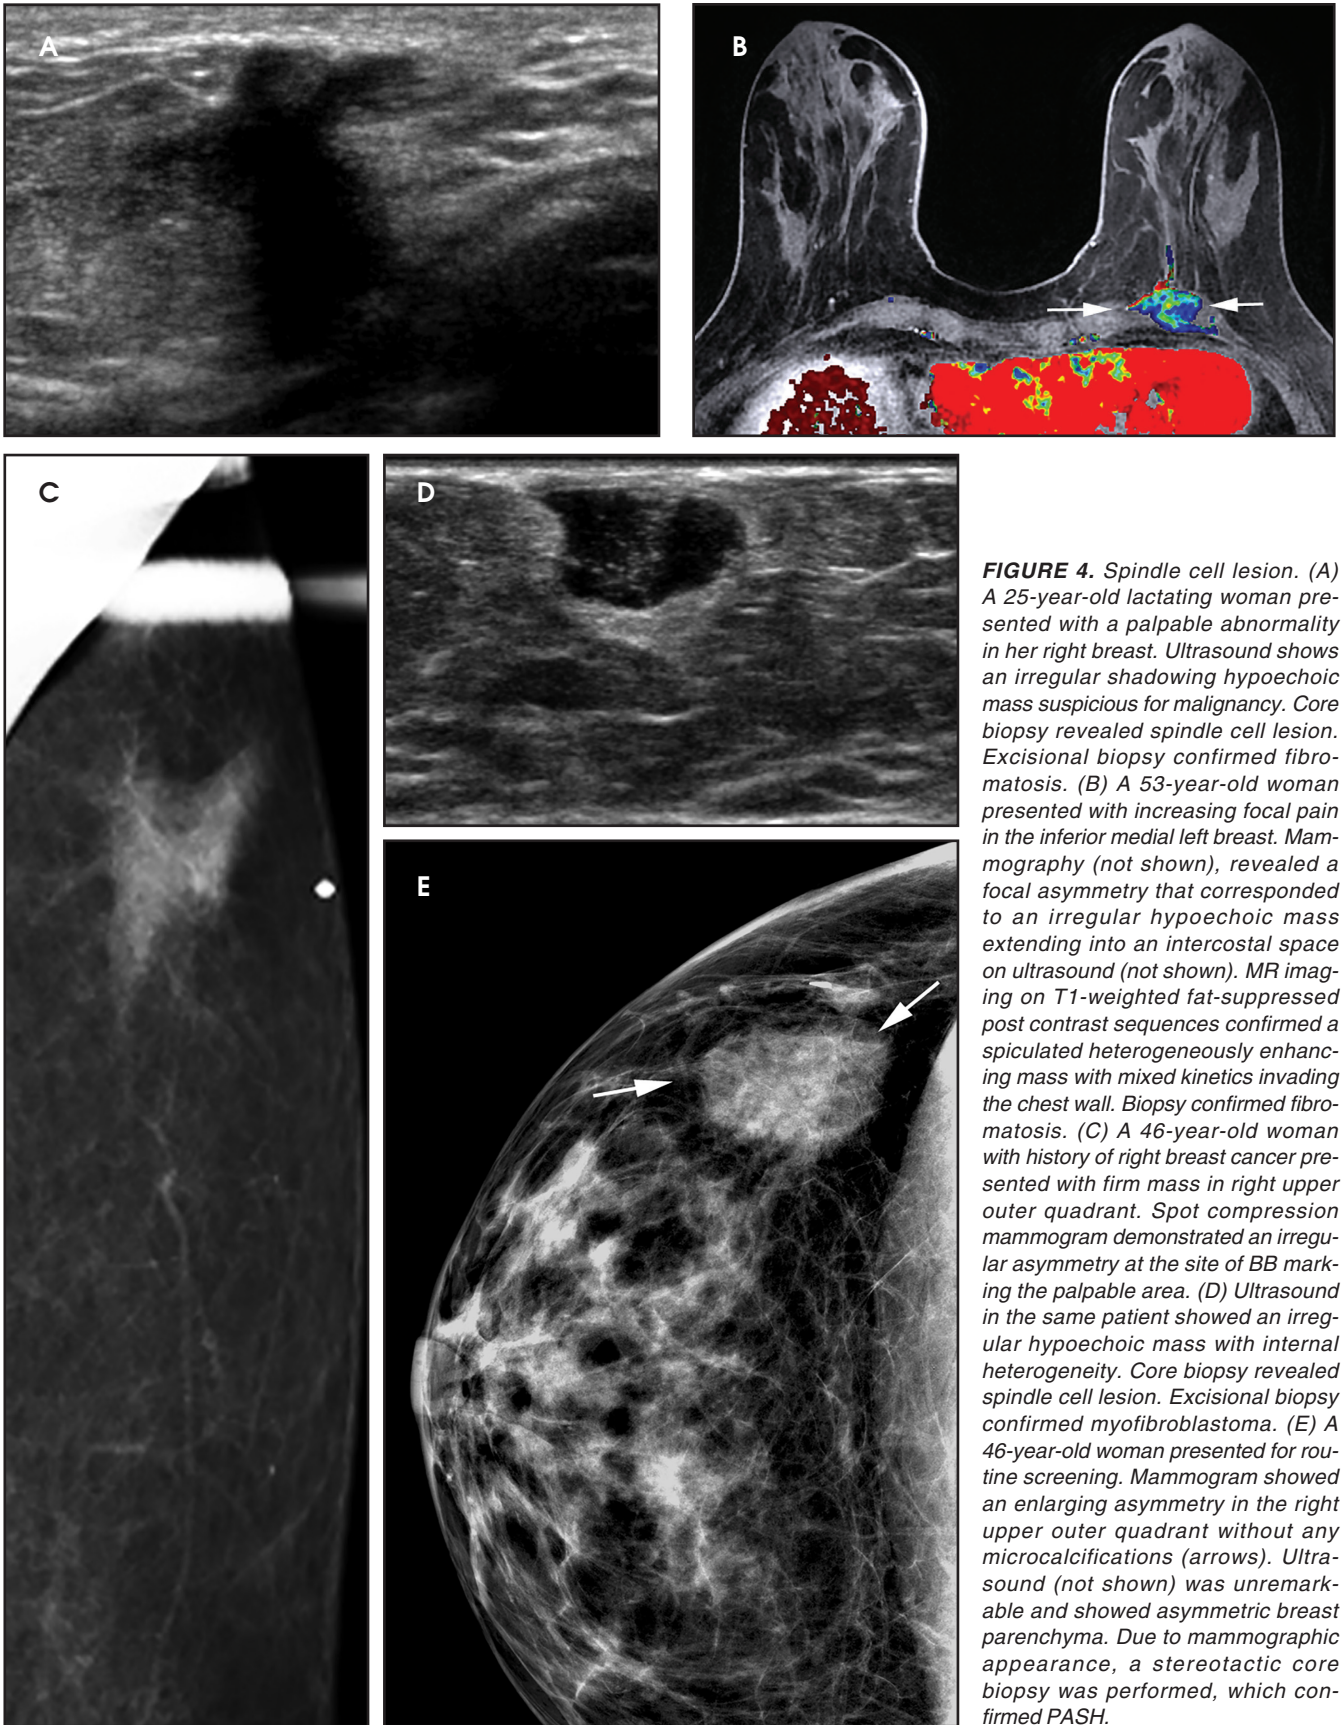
Spindle cell lesion. (A) A 25-year-old lactating woman presented with a palpable abnormality in her right breast. Ultrasound shows an irregular shadowing hypoechoic mass suspicious for malignancy. Core biopsy revealed spindle cell lesion. Excisional biopsy confirmed fibromatosis. (B) A 53-year-old woman presented with increasing focal pain in the inferior medial left breast. Mammography (not shown), revealed a focal asymmetry that corresponded to an irregular hypoechoic mass extending into an intercostal space on ultrasound (not shown). MR imaging on T1-weighted fat-suppressed post contrast sequences confirmed a spiculated heterogeneously enhancing mass with mixed kinetics invading the chest wall. Biopsy confirmed fibromatosis. (C) A 46-year-old woman with history of right breast cancer presented with firm mass in right upper outer quadrant. Spot compression mammogram demonstrated an irregular asymmetry at the site of BB marking the palpable area. (D) Ultrasound in the same patient showed an irregular hypoechoic mass with internal heterogeneity. Core biopsy revealed spindle cell lesion. Excisional biopsy confirmed myofibroblastoma. (E) A 46-year-old woman presented for routine screening. Mammogram showed an enlarging asymmetry in the right upper outer quadrant without any microcalcifications (arrows). Ultrasound (not shown) was unremarkable and showed asymmetric breast parenchyma. Due to mammographic appearance, a stereotactic core biopsy was performed, which confirmed PASH.
